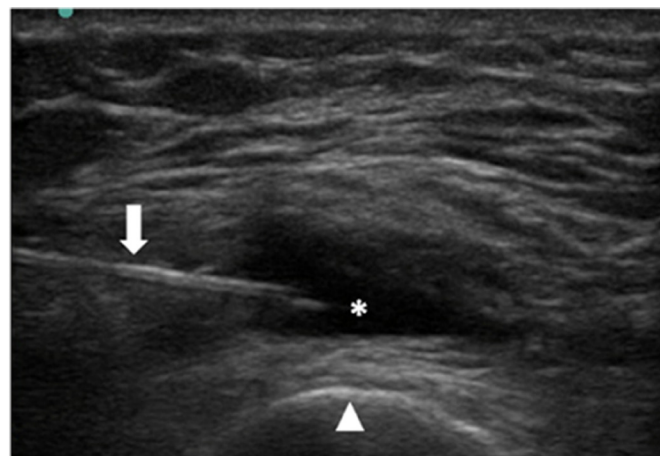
Ultrasonic image at injection: ↓ shows the needle, * shows the suprapatellar bursa, Δ shows the femoral cortical.
